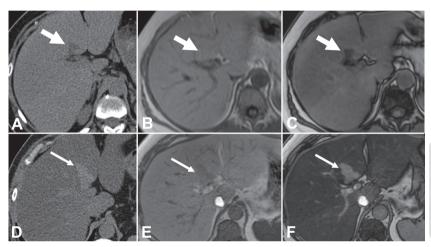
Hepatic steatosis. A to C) Area of focal steatosis on pre-contrast CT (A), in-phase T1-weighted MRI (B), and out-of-phase T1-weighted MRI (C). D to F) Area spared of steatosis (another patient) on pre-contrast CT (D), in-phase T1-weighted MRI (E), and out-of-phase T1-weighted MRI (F).
